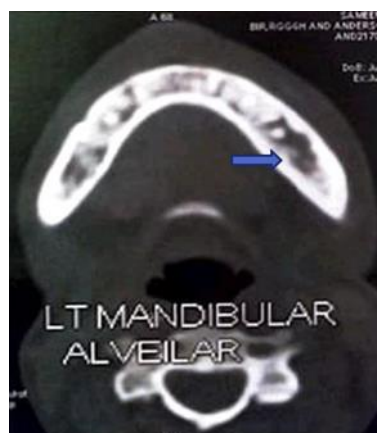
Radiographic Investigations
